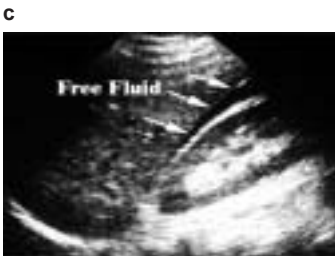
a,b. The standard four locations for sonographic windows.
